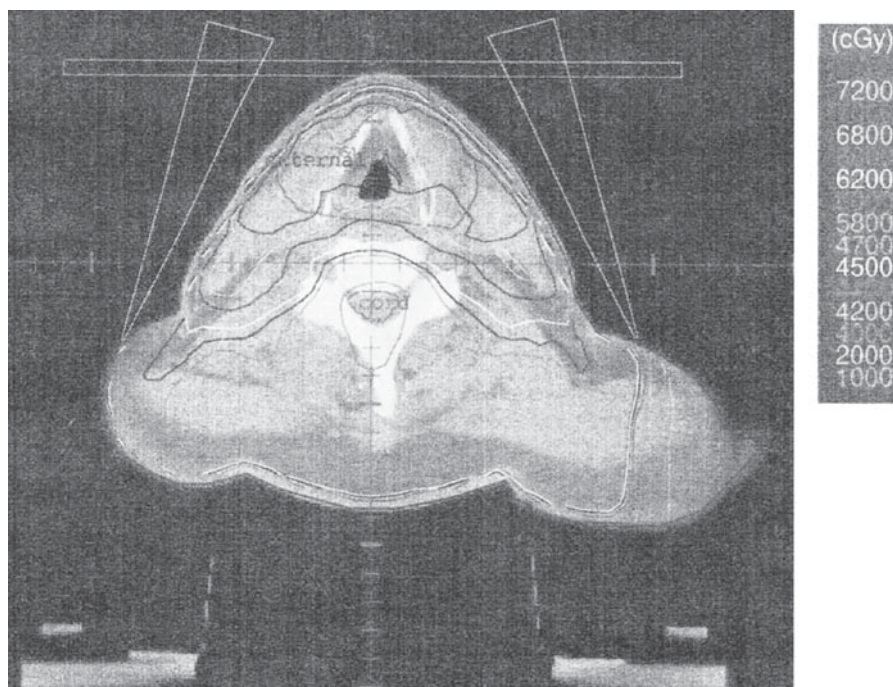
Axial CT scan image through the thyroid gland in a patient with thyroid bed recurrence after thyroidectomy for a papillary thyroid cancer. A dose of 70 Gy was administered to the thyroid recurrence encompassed by the innermost *dark purple line*. A dose of 66 Gy was
